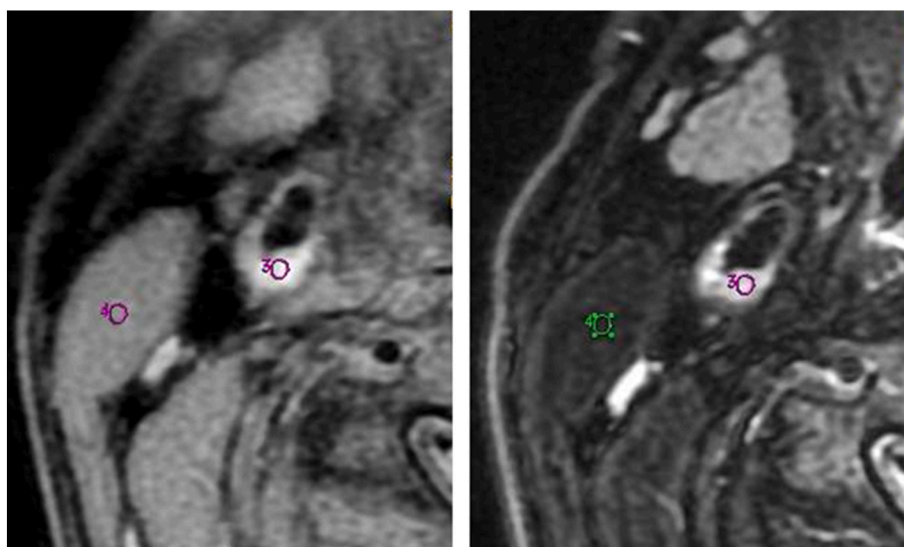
The region of interest is set to the plaque in cervical carotid artery and sternocleidomastoid muscle in both T1 (left) and T2 (right) weighted image of BB-MRI.
